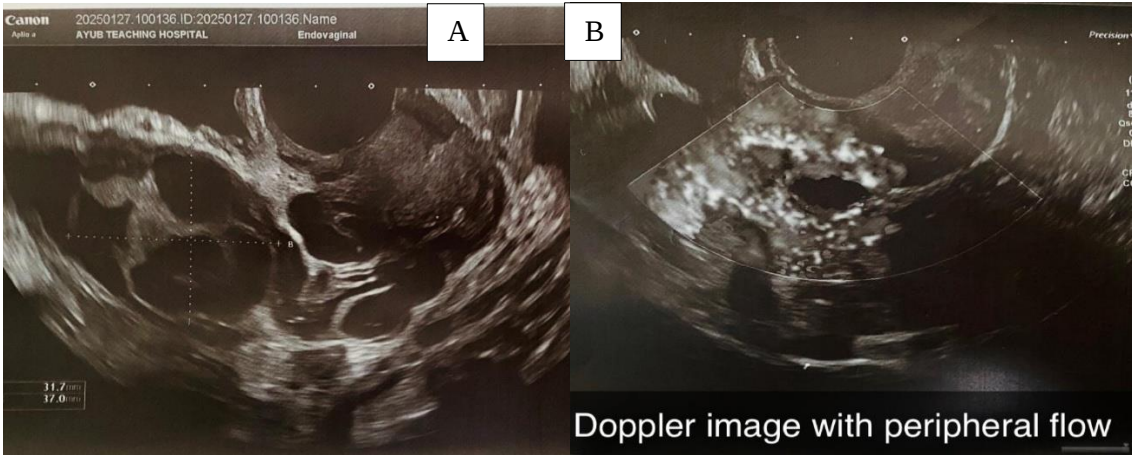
Grey scale and Color Doppler Transvaginal Ultrasound images of the Ectopic Pregnancy
